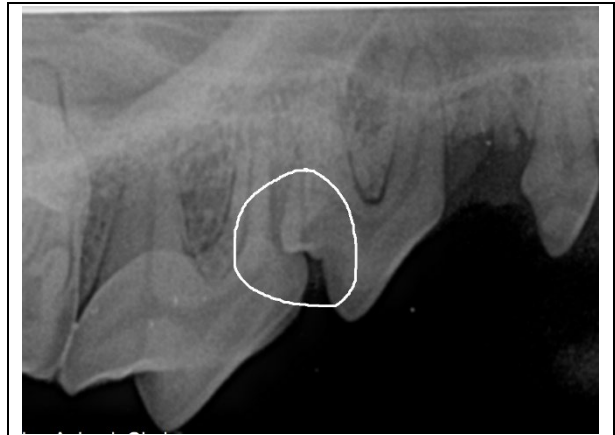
In the radiograph, you can see how the distal shoulder of the 3<sup>rd</sup> premolar is trapped in the mesial furcation of the 4<sup>th</sup> premolar. What other abnormalities do you see in this radiograph? (answer on last page).
